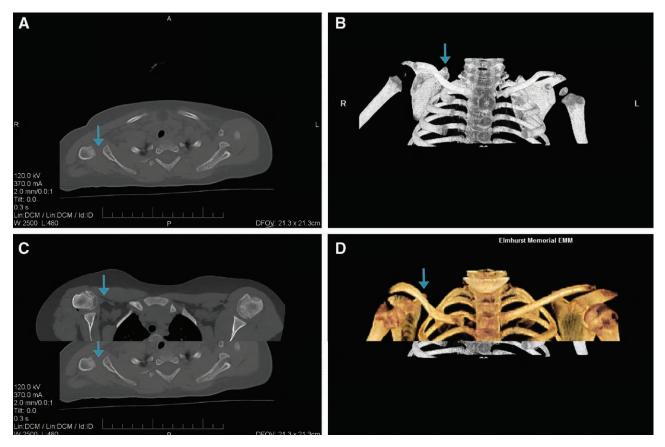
Axial CT scans of the affected shoulder of an OBPI patient before and 10 years after triangle tilt surgery. A, 2D- CT image before triangle tilt surgery. The arrow head pointing posterior subluxation of the humeral head and incongruity of the glenohumeral joint (left). C, CT image after triangle tilt surgery showing improvement. B, 3D- CT image of the same patient before triangle tilt surgery, the arrow head pointing the scapular hypoplasia, elevation and rotation (SHEAR) deformity of the affected (left) side. D, No SHEAR deformity after triangle tilt surgery.
